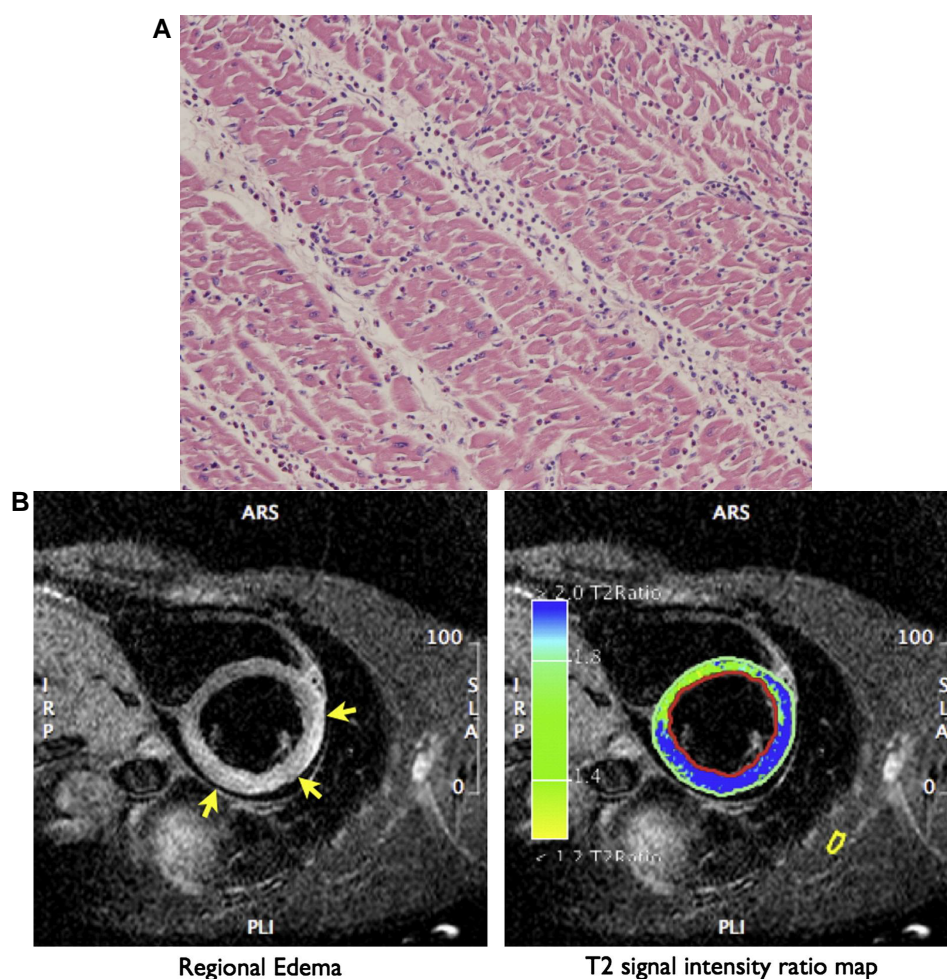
(A) Interstitial myocarditis with oedema, in the absence of myocardial necrosis. (B) T2-weighted short-axis view of myocardial oedema by cardiac magnetic resonance in acute myocarditis.
